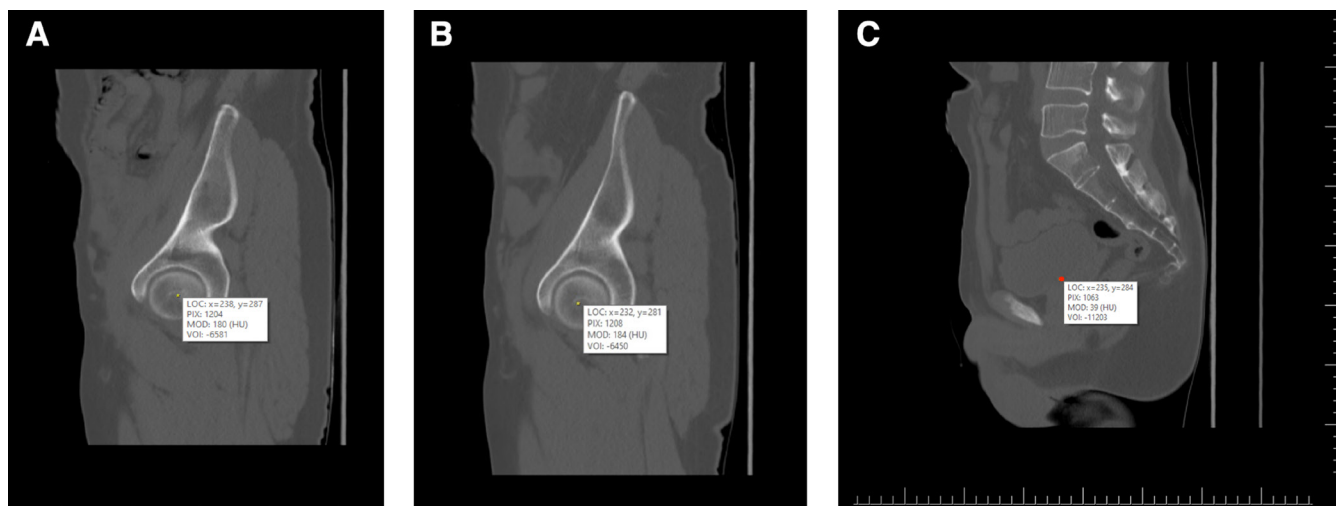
(A) Sagittal slice of pelvic computed tomography (CT) image of the same patient showing coordinates of the right femoral heads. (B) Sagittal slice of pelvic CT with coordinates of the left femoral head. (C) (Changed) Midsagittal CT slice of the patient. The point with average coordinates of the femoral head center determines the midpoint of the hip axis.
